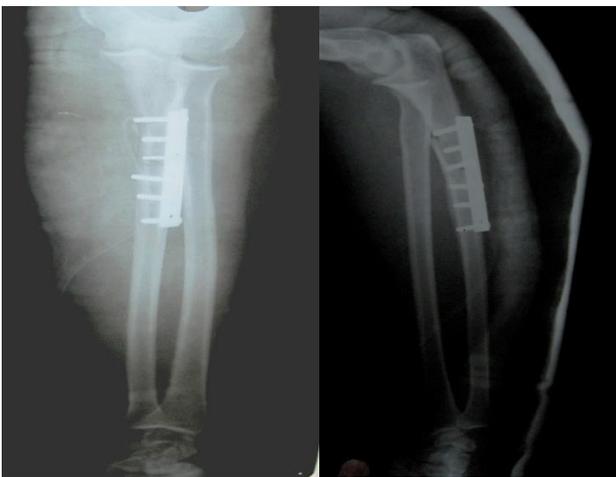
Immediate post-operative X-rays.
